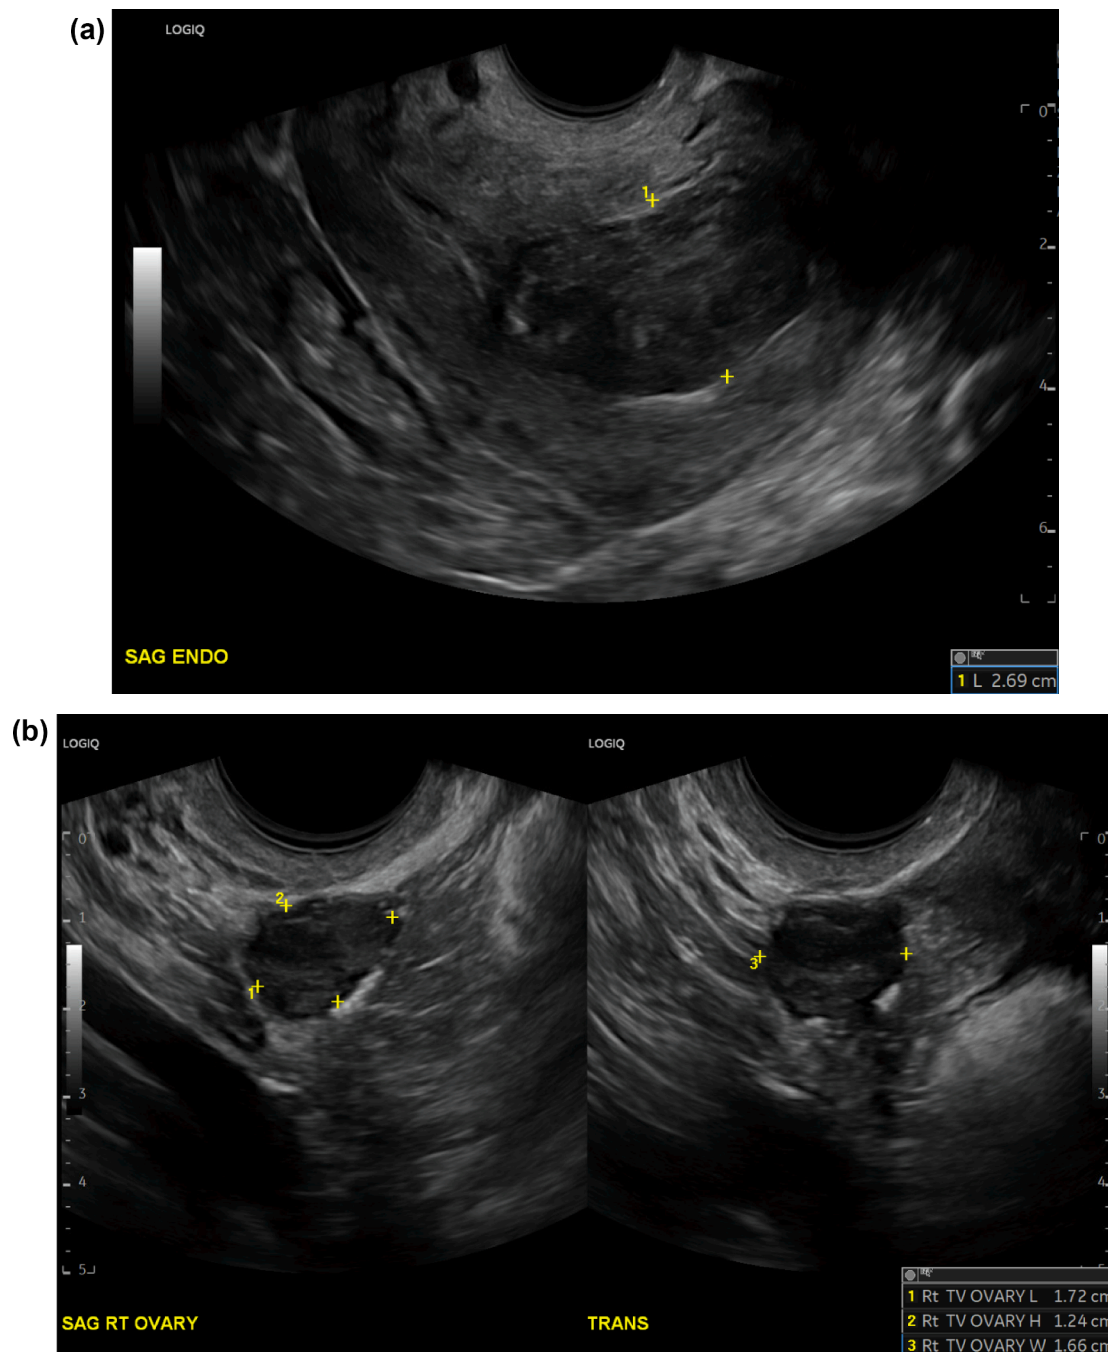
(a) Sagittal ultrasound demonstrating intracavitary mass. (b) Two views of right ovary normal in size. (c) Two views of left ovary and associated hypoechoic lesion.
